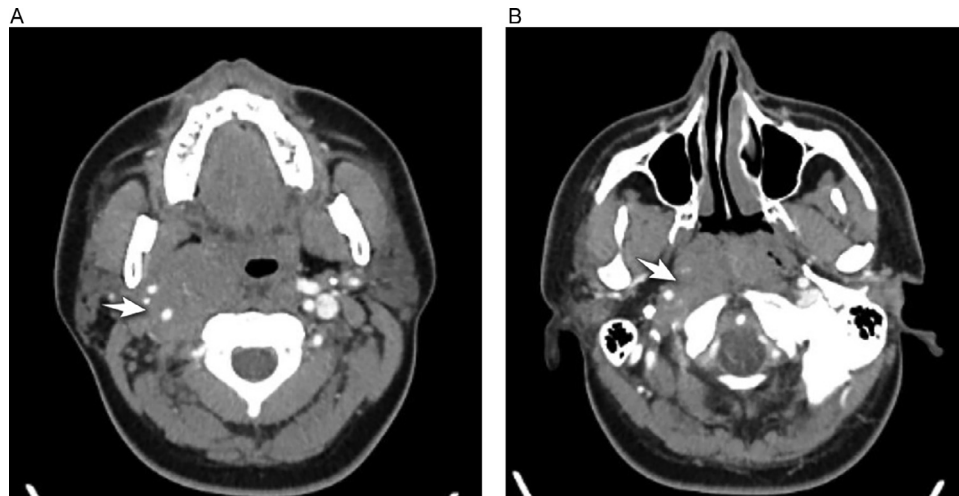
Contrast enhanced CT scan. (A) A slightly enhancing mass is observed in the right carotid space, causing splaying of the internal and external carotid arteries with parapharyngeal space obliteration, (B) The mass extends into the nasopharynx and superior retropharyngeal space.
